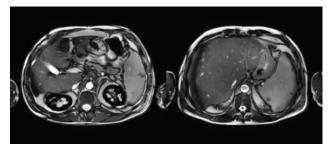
MRI abdomen – Day 2 of persistent transaminitis. The images demonstrate hepatomegaly with altered perfusion and attenuated but patent hepatic vasculature; splenomegaly with splenic infarcts; and renal cortical hemosiderosis, which can be seen with paroxysmal nocturnal hemoglobinuria.
